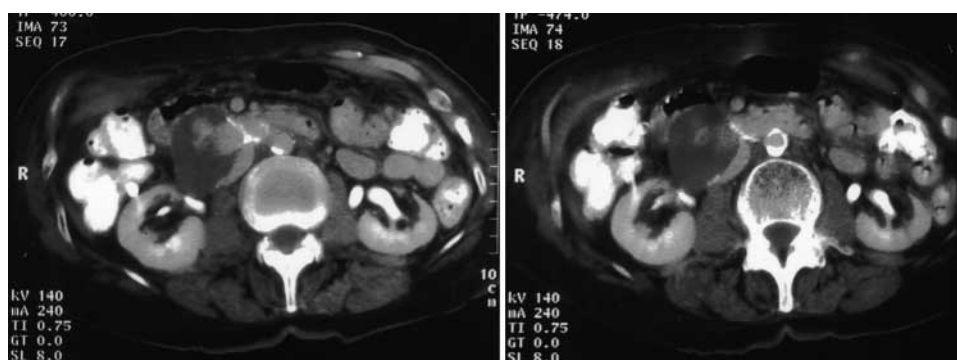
Abdominal computed tomography scan with intravenous contrast demonstrating right aortorenal vein graft aneurysm with laminated mural thrombus.
